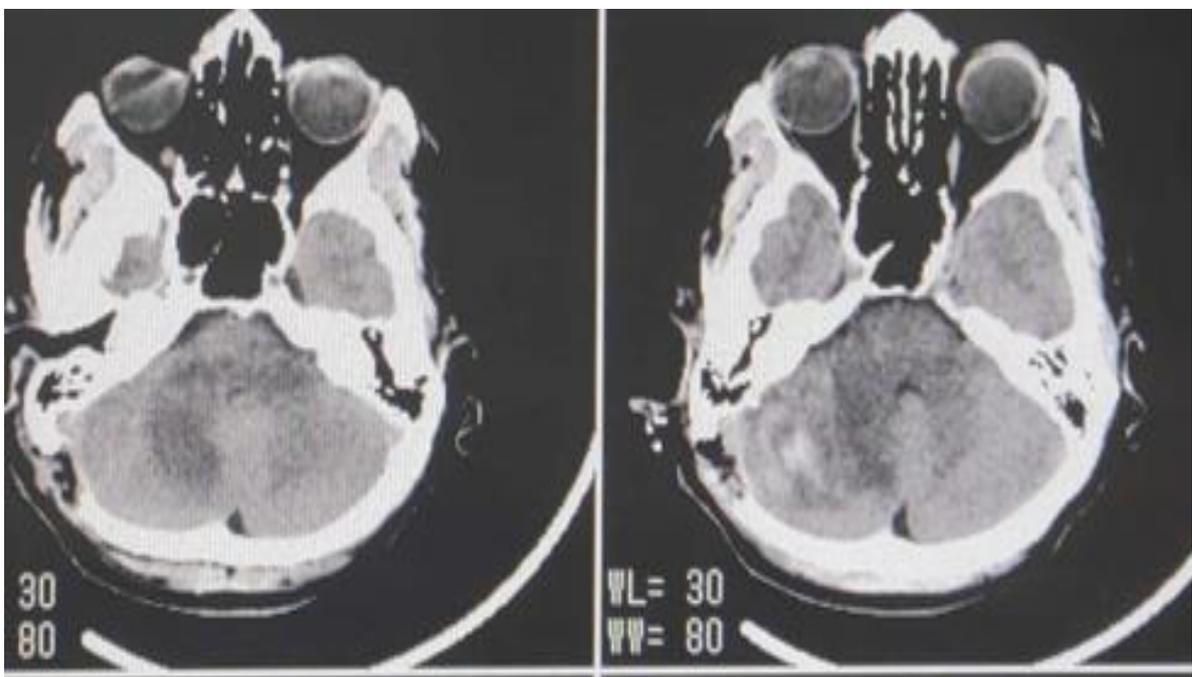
Postoperative CT brain without contrast
